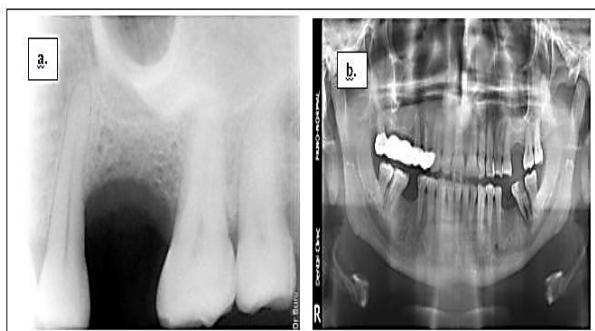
Pre-operative radiographic examination (a) Pre-operative RVG #26, (b) Pre-operative OPG
